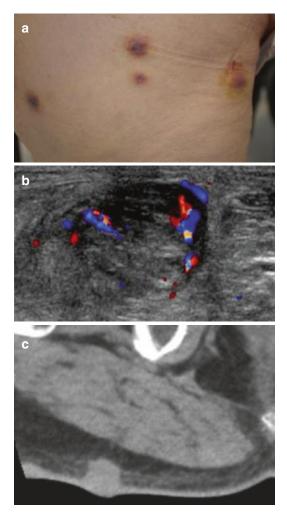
Angiosarcoma in a 70-year-old men. (a) Clinical photograph. (b) Axial color Doppler image. (c) Computed tomography. (a) Clinical appearance of numerous skin lesions. (b) Ultrasound with color Doppler shows nodular superficial tissue mass, slightly hypoechogenic and predominately peripheral flow within the soft tissue mass. (c) Computed tomography demonstrates a non specific subcutaneous nodular lesion
